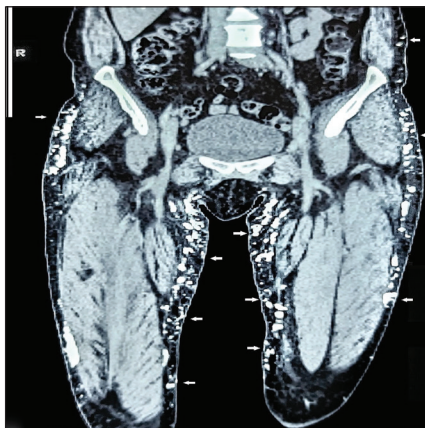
CT scan: Coronal section showing coarse subcutaneous calcifications in flanks and thighs (white arrows).
